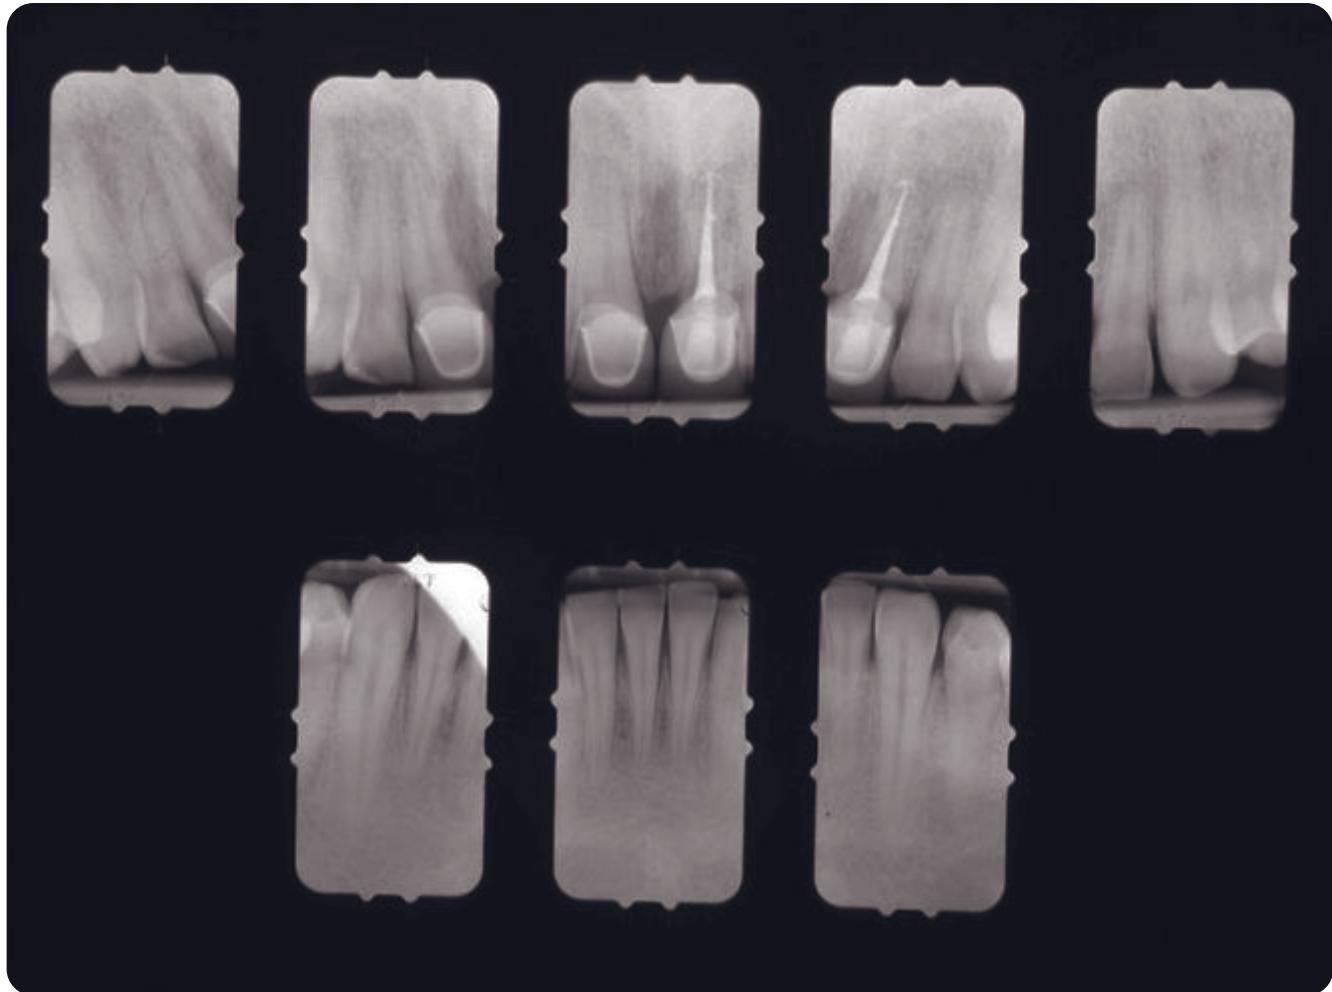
Pretreatment radiographs of the anterior teeth suggesting compromised root integrity of tooth 9.
